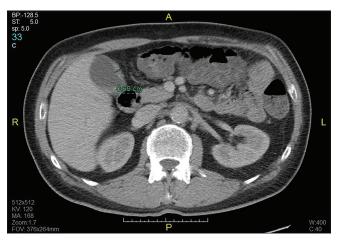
Abdominal computed tomography showed a thickening of the gallbladder wall, but no mass (0.69 cm)
